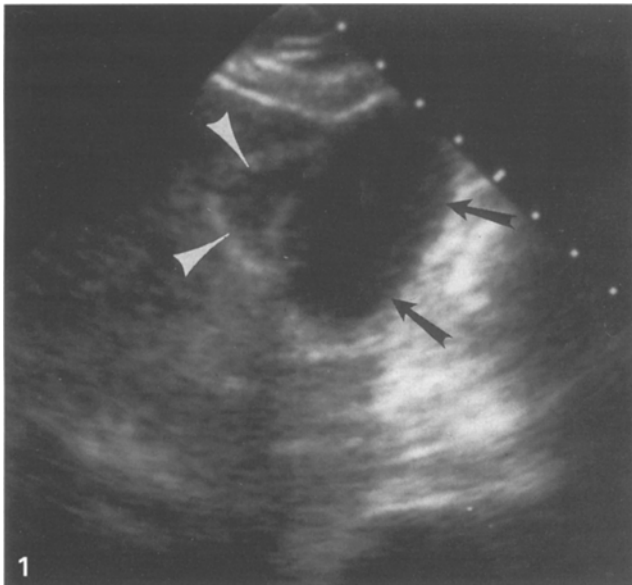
Ultrasound of the liver shows a distended gallbladder (*arrows*) and a pericholecystic fluid collection (*arrowheads*) in a 77-year-old man with bladder cancer, hypertension, and recent myocardial infarction, who had developed sepsis while comatose and on a ventilator. Following percutaneous cholecystostomy his fever and white blood count decreased, but he remained comatose and died.
